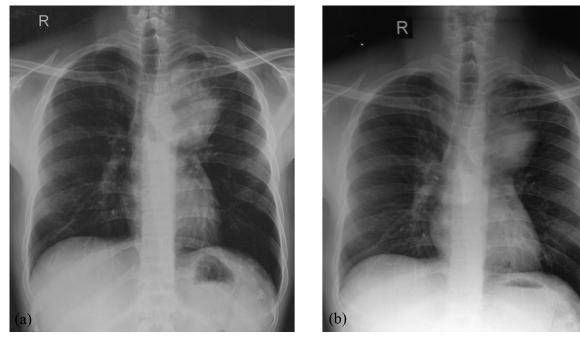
The chest radiograph at the start of treatment (a) showing a left apical opacity. Reduction in the size of the lesion (b) after 3 weeks treatment with liposomal Amphotericin B
